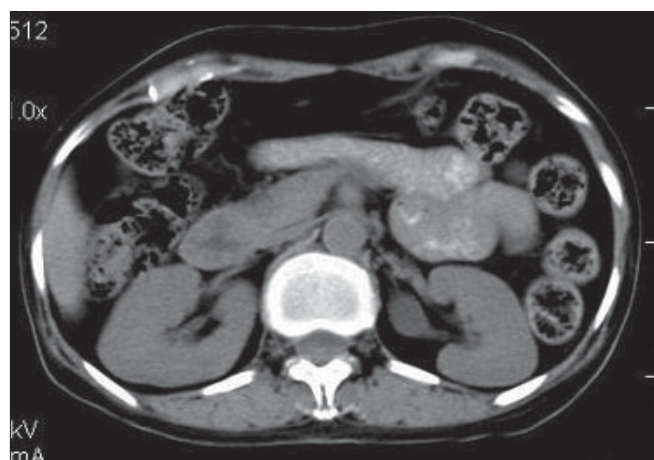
CT scan of the abdomen showing a well-enhanced, soft tissue lesion 56 x 40 x 30 mm in size with a speck of calcification in the tail of the pancreas
